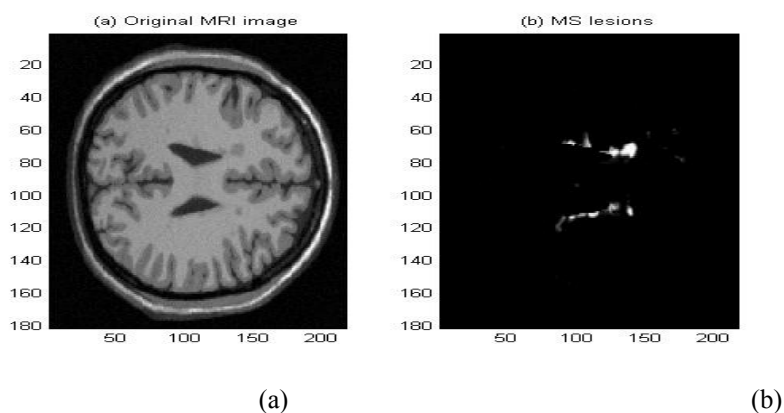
(a) MRI image with (b) MS lesions
